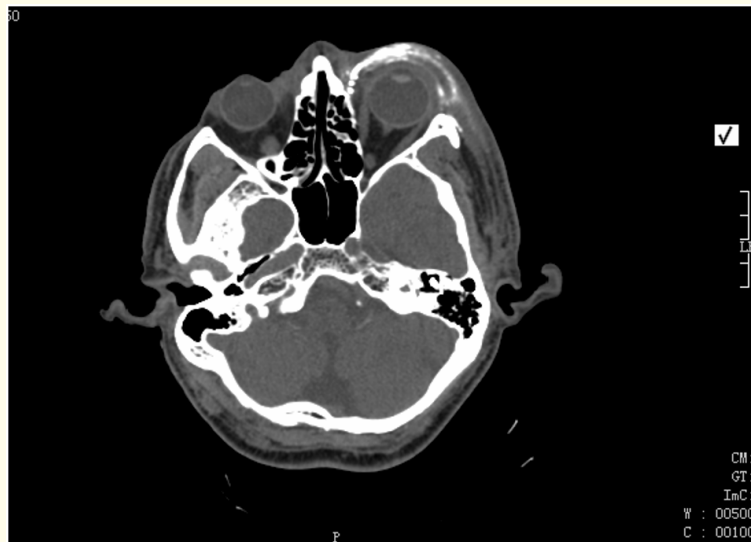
CT axial (1a) and coronal (1b) views demonstrating a left sided periocular hyperdense subcutaneous infiltration (white arrow). No evidence of post-septal involvement.
